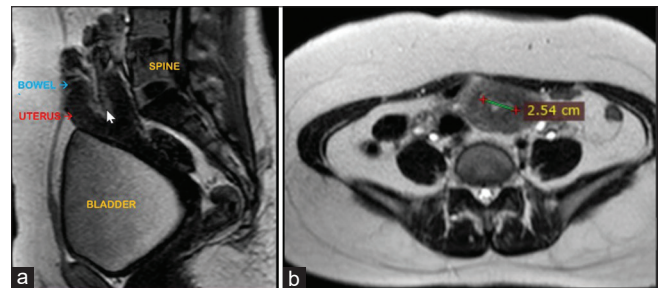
(a) Sagittal view of abdominal magnetic resonance imaging (MRI) showing bowel (blue) herniation (arrow) into the uterine fundus (red). (b) Transverse view of abdominal MRI showing uterine defect of 2.54 cm
